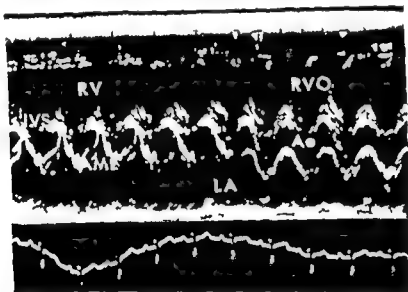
M mode scan between the mitral and aortic valves. Moving the beam from the mitral direction (left) to the aortic direction (right) the interventricular septum becomes the anterior wall of the aorta at the same level but a difference of the level between the anterior mitral leaflet and the posterior wall of the aorta is found. The leaflet is anteriorly displaced and the distance between the D point of the leaflet and the septum is smaller than the diameter of the aorta. This is an echocardiographic representation of the angiographic "goose neck" sign. An enlargement of the right ventricle (RV) and the right ventricular outflow tract (RVO) is also found. Ao = aorta.
